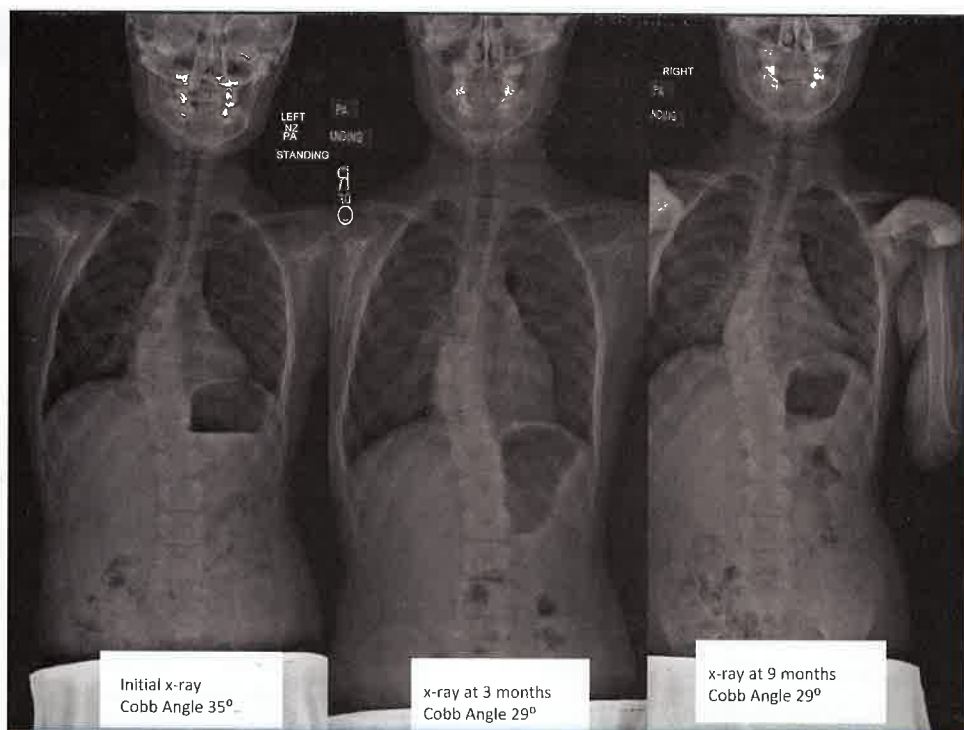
X-rays showing improvement/stabilization of Cobb Angle over the 9-month period.
